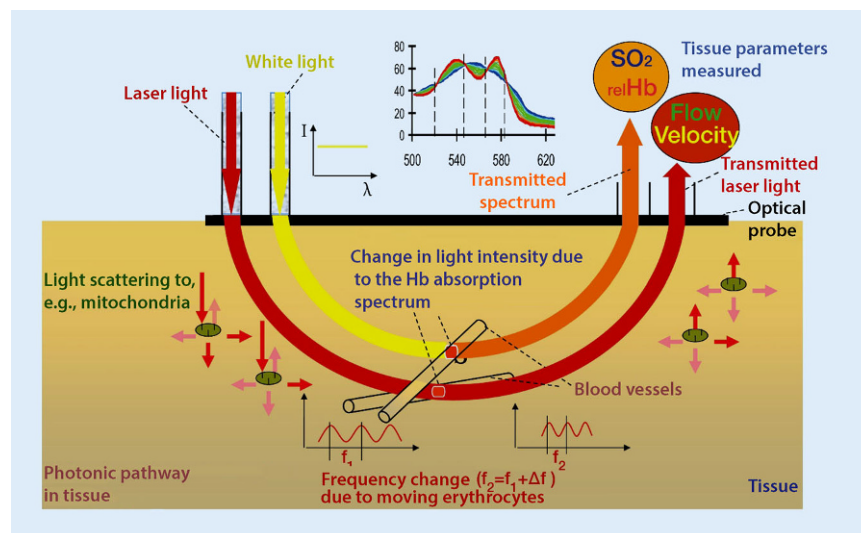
▲ The O₂C measuring principle: a combination of white light spectrometry and laser Doppler flowmetry (courtesy of LEA Medizintechnik GmbH)
